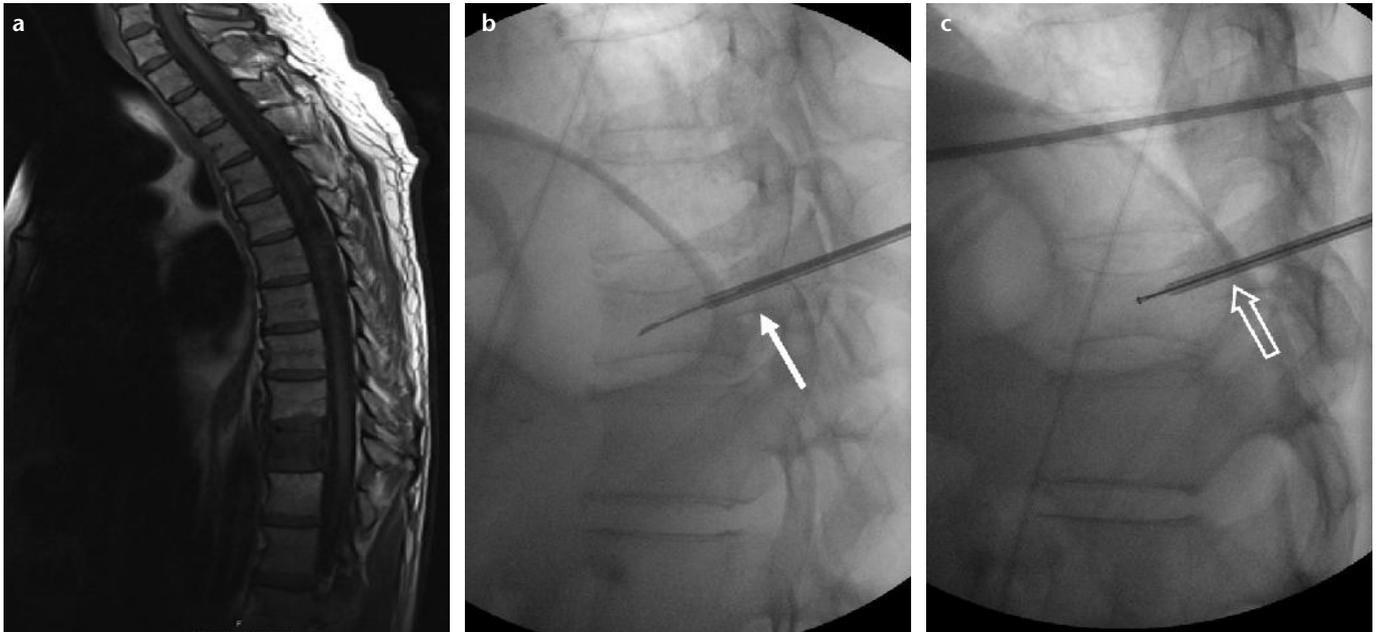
a–c. Images of a 79-year-old female with breast cancer and a metastatic vertebral fracture of T12 who underwent bone biopsy followed by coblation and vertebroplasty. Sagittal T1 MR image (a) demonstrates vertebral height loss and marrow replacement. Sagittal fluoroscopic image (b) with a 13-gauge coaxial delivery system placed via a transpedicular approach with the biopsy needle deployed (arrow). Deployment of the coblation probe (c) into the delivery port with its tip protruding beyond the cannula (arrow).
